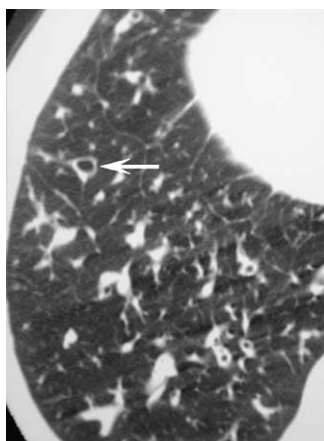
HRCT assessment of bronchiectasis: the “signet ring” sign. Coned axial HRCT image shows a dilated bronchus (arrow) in cross-section. Note that the internal diameter of the bronchus exceeds the diameter of the adjacent pulmonary artery.
